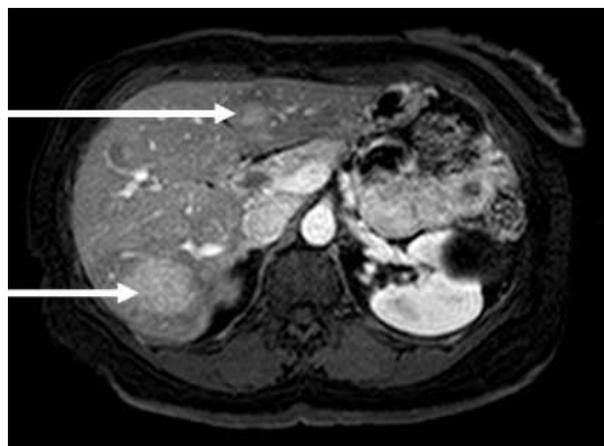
MRI of a patient with pancreatic neuroendocrine tumor spread to the liver (arrows).
